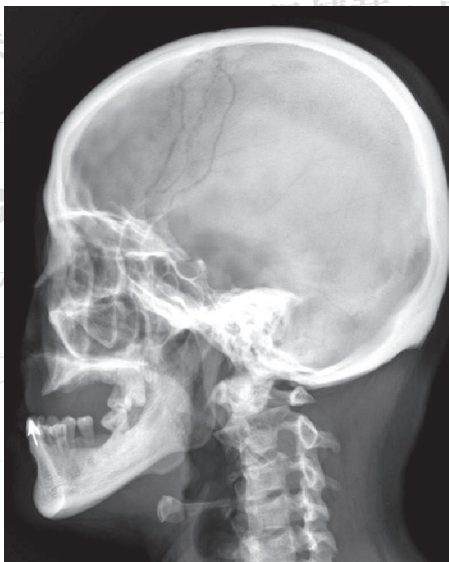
Lateral cephalometric radiograph revealed skeletal Class III jaw relationship.
